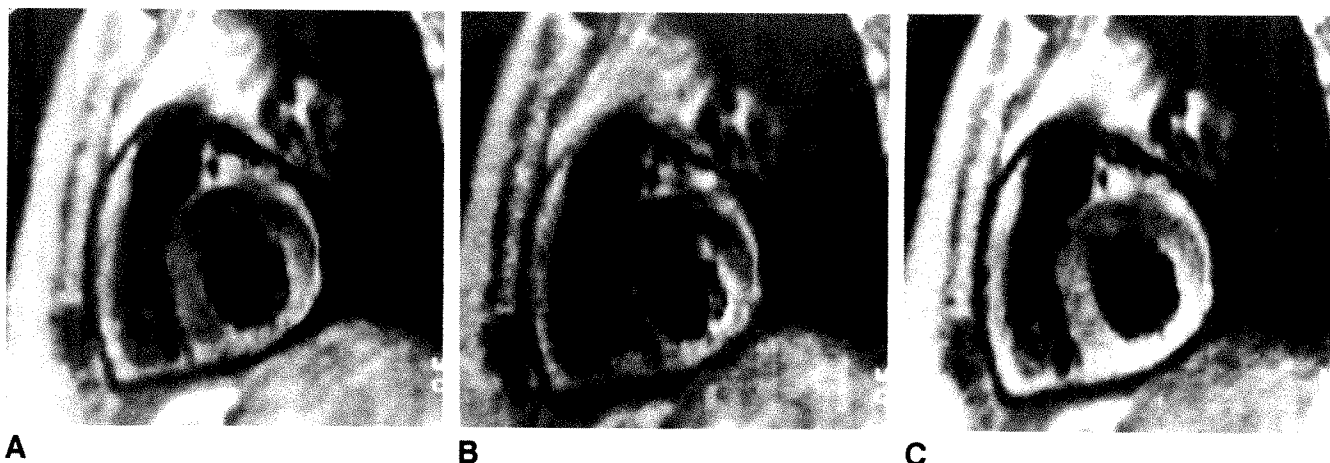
MR image shows moderately increased signal intensity at inferoposterior region without Gd-DTPA. Marked contrast enhancement was obtained after Gd-DTPA administration in this region at 12 days from onset of infarction. Pulse sequences were (A) T1, SE 1000/35; (B) T2, SE 1000/70; and (C) T1 with Gd, SE 1000/35.
